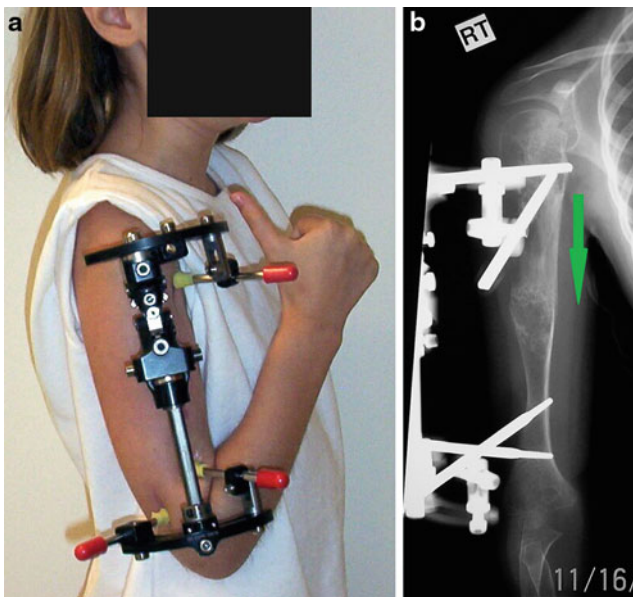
(a) Clinical picture at the end of lengthening and correction. (b) AP X-ray showing correction of deformity and 9 cm regenerate (*green arrow*)
